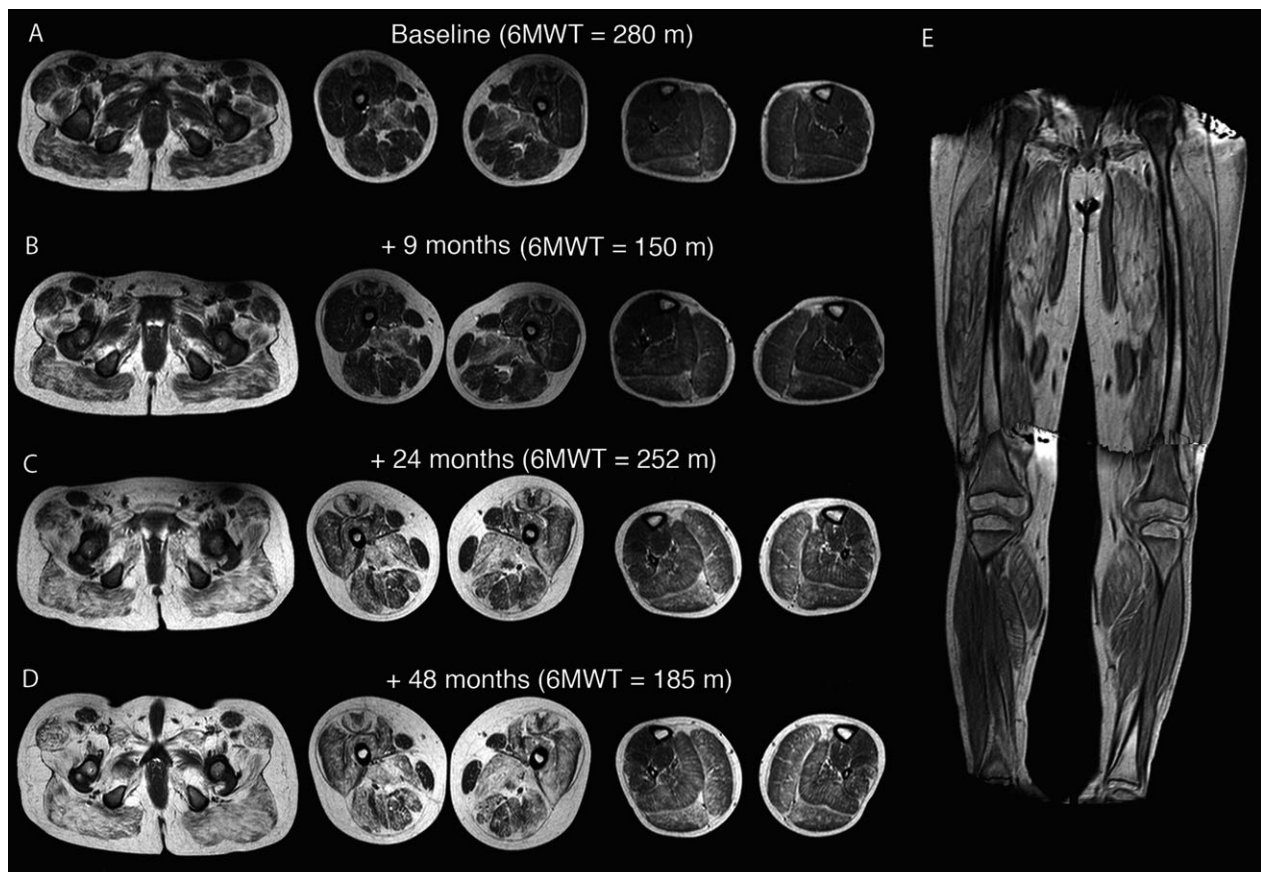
Representative MRI images acquired longitudinally on the same patient. A–D) Axial Spin Echo T1-weighted images of glutei (left column), thighs (middle column), and calves (right column) from a Duchenne muscular dystrophy patient at different time points (A, B, C, D). Please notice the progression over time of atrophy in thighs, hypertrophy in calves, and fat infiltration in both thighs and calves. A representative coronal view of 3D THRIVE from the same patient is also shown in E. 6MWT distance measured 1 day prior to each MRI examination is reported for reference. The patient performed a higher distance in C than in B, due to the lack of active collaboration. 6MWT: 6-min walking test.
